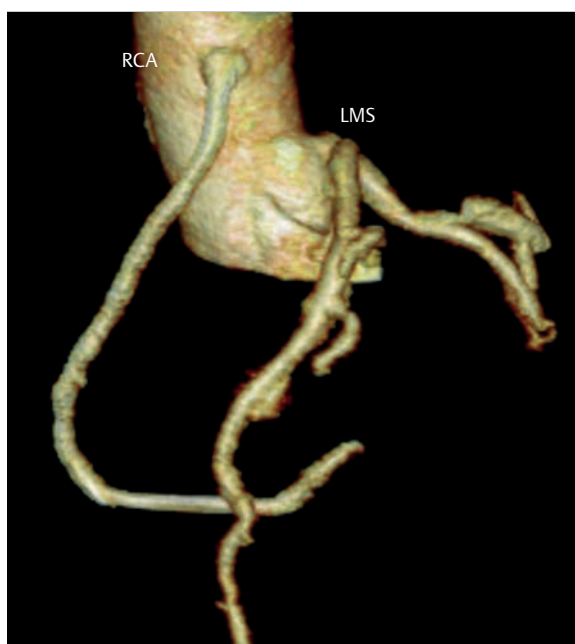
Superior origin of the right coronary artery from the ascending aorta. Fifty-one-year-old female patient with atypical complaints of angina pectoris; coronary CTA. The coronary artery does not originate from the right coronary sinus. The left main branch originates normally from the left coronary sinus.
